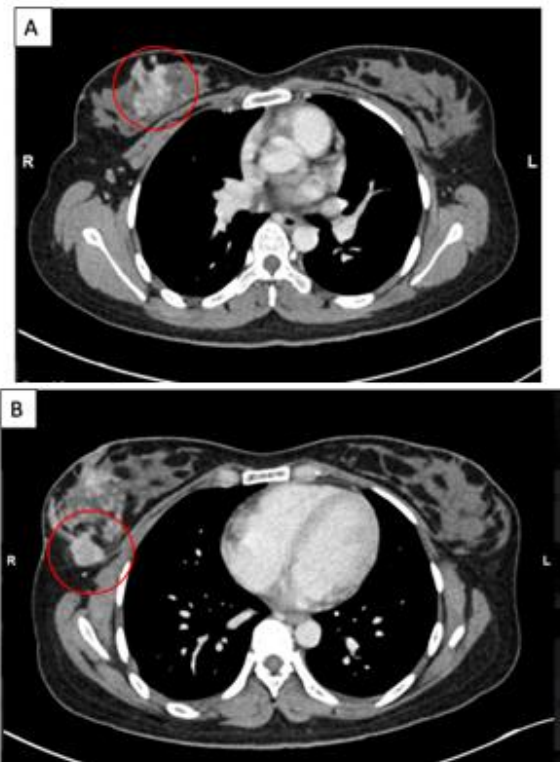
Axial CT thorax. [A] A well-defined heterogenous enhancing lesion at right upper outer quadrant with spiculated margin. The mass has clear fat demarcation with right pectoralis muscle. [B] An enlarged right axillary node seen in continuity with lateral fascia of pectoralis muscle.
